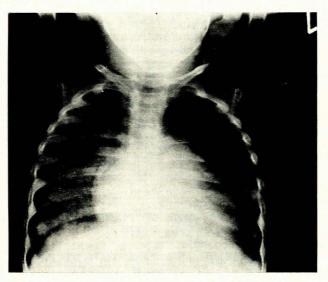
Anteroposterior view of chest radiograph showing cardiomegaly with lung congestion.
